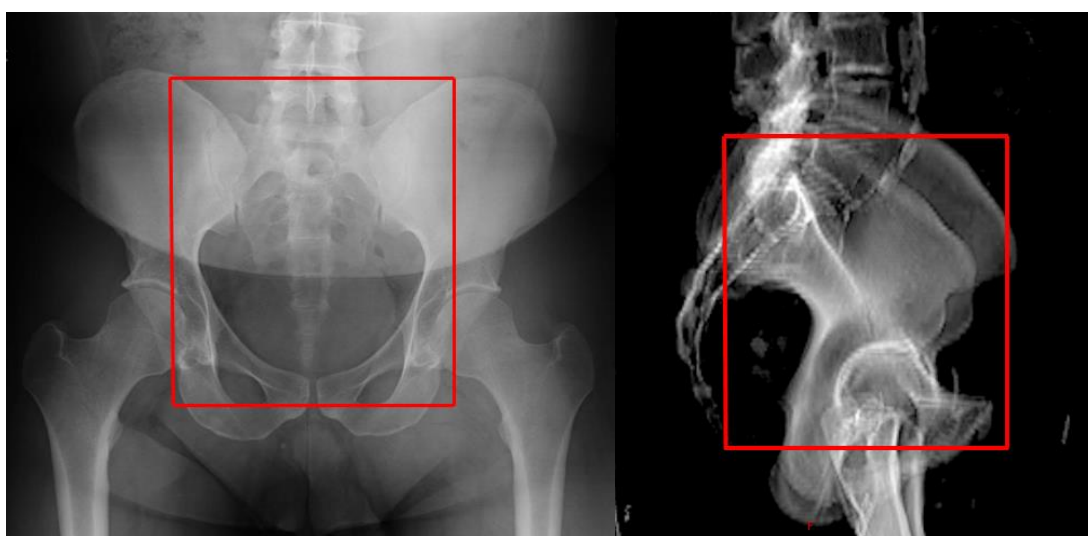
Cervical pelvic RT treatment fields on anterior-posterior and lateral X-Rays.
